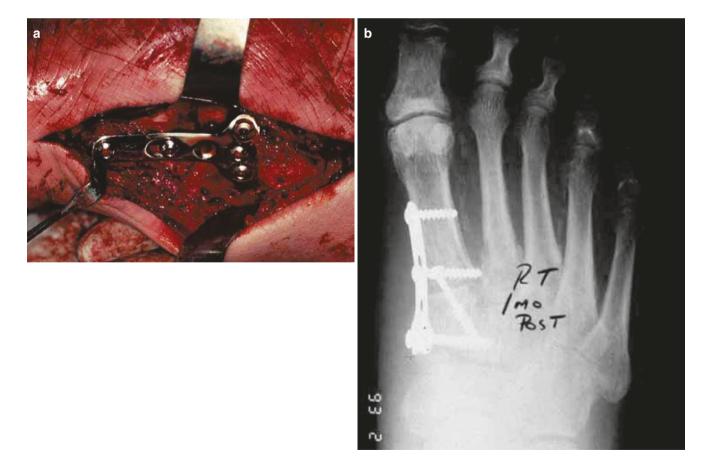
(a) A T-plate with an interfragmentary screw is another acceptable form of fixation of the first metatarsal-medial cuneiform joint in the presence of unstable Charcot joint. (b) Radiograph of patient with T-plate and interfragmentary screw across the first metatarsal-medial cuneiform joint
